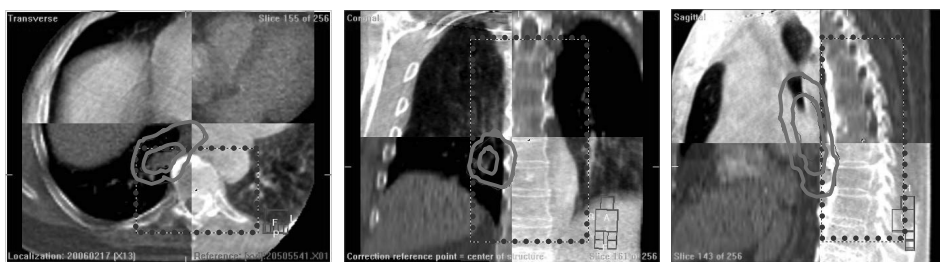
Match of the planning CT and the Cone-Beam CT (CBCT) whereby a user-defined 3-D region of interest (blue dashed line) was positioned around the vertebra. The inner and outer red line represents the gross target volume and clinical target volume, respectively.
